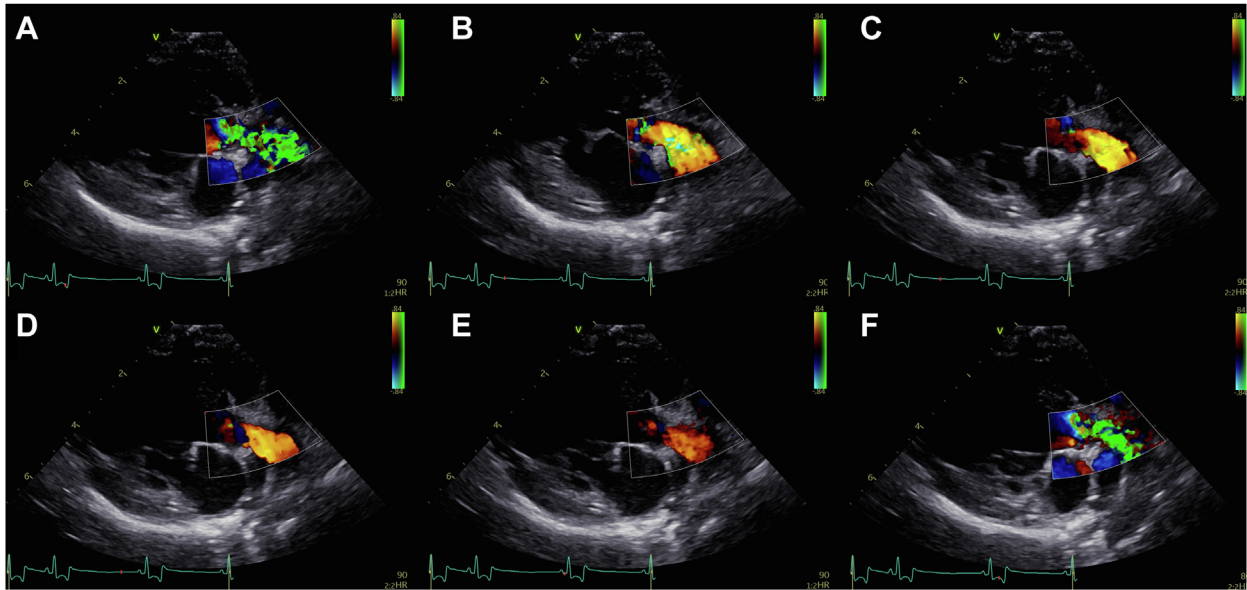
Two-dimensional TTE, right parasternal long-axis view of the aorta with color flow Doppler, demonstrates turbulent flow in the ascending aorta during systole (A, F), consistent with aortic stenosis and retrograde flow in the ascending aorta in early (B) and mid (C, D) diastole and late diastole (E).
